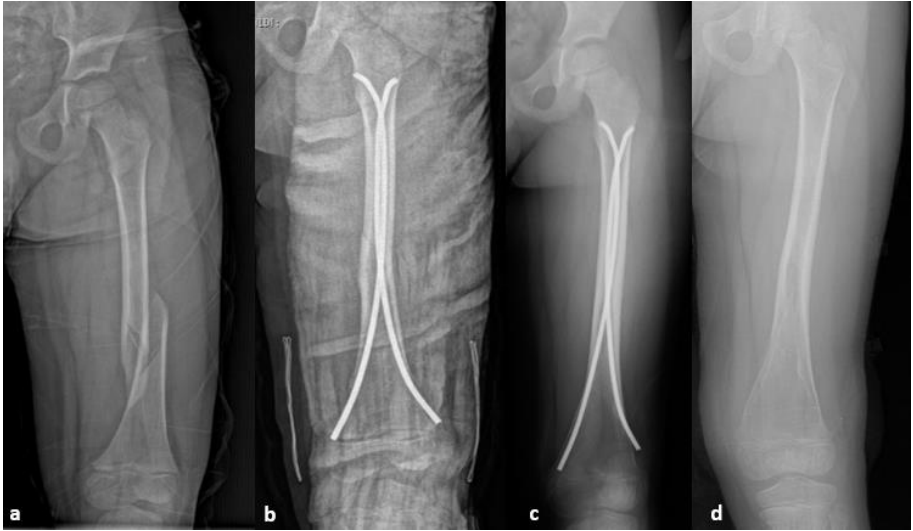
a-Radiography with a diagnosis of Class 3 pediatric left femur fracture.
